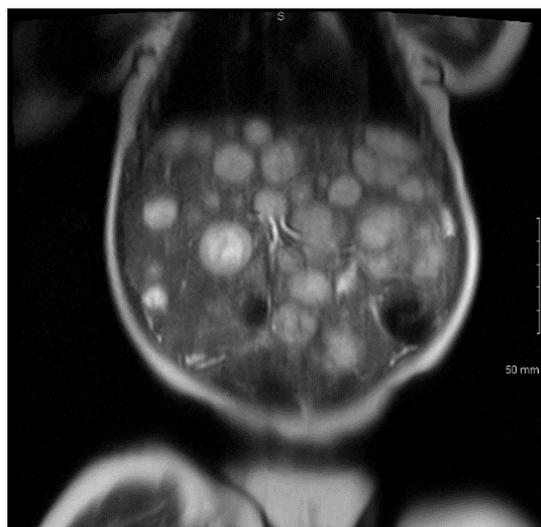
MRI abdomen showing hepatomegaly secondary to innumerable hepatic hemangiomas.
